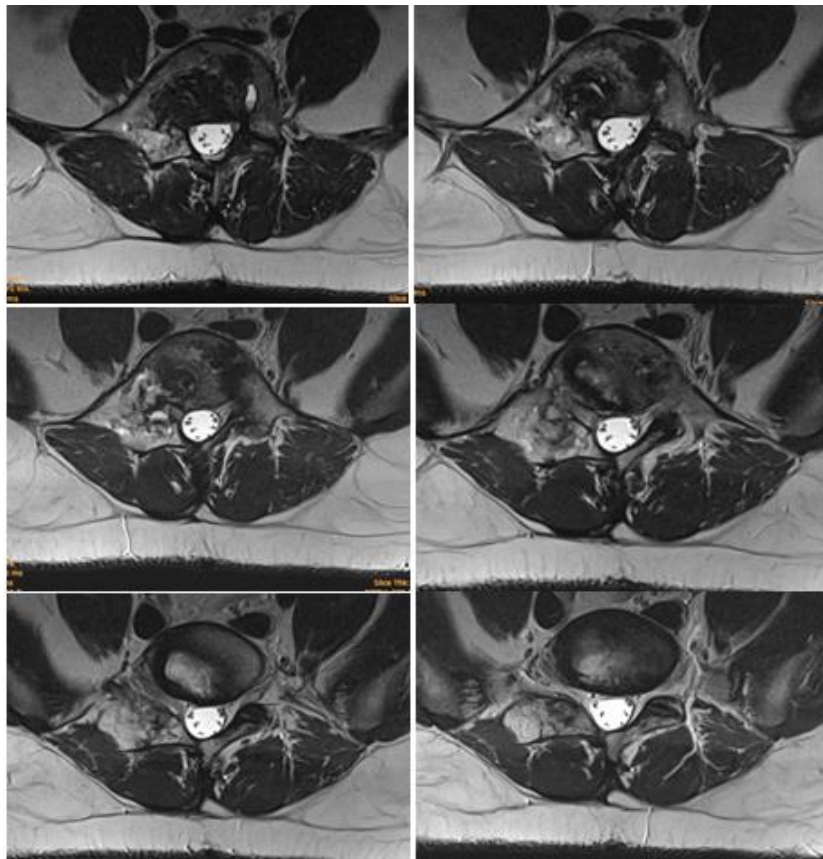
MRI after 2 years of IMRT/ 26.06. 2025 - Deformity of L5 on the right with a residual formation with reduced axial dimensions of 4.01cm/7.64cm compared to the examination of 15.11.2024.
